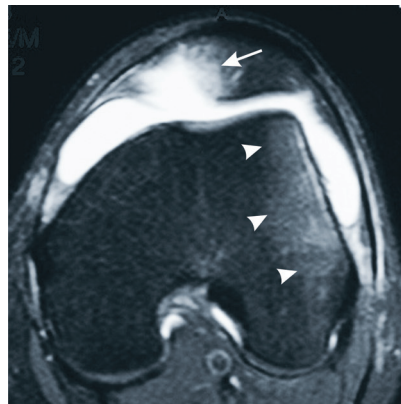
T2-weighted MRI with fat suppression in the axial plane, in which bone edema is observed in the medial portion of the patella (arrow) and on the periphery of the lateral femoral condyle, which is typical of a recent episode of transitory lateral dislocation of the patella. Also note the presence of joint effusion.
